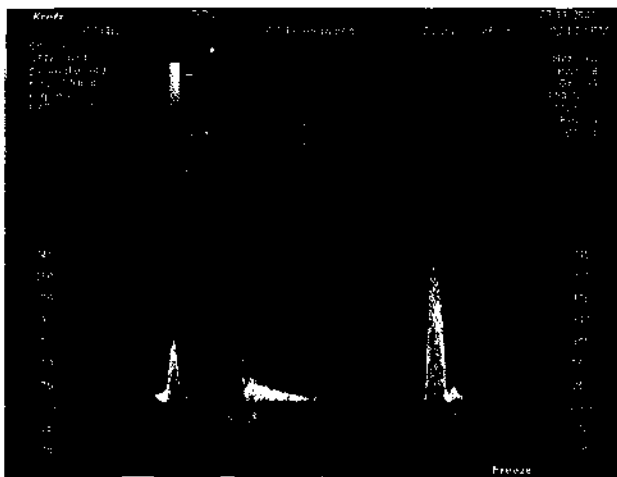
Celiac axis stenosis. Celiac axis stenosis in isolation is rarely symptomatic because of the generous anastomoses in the gut's blood supply, but, because it usually occurs in arteriopathies, two or more of the arteries are often affected. The acceleration of the blood crossing the narrowing produces fast flow on the Doppler study (here rising to more than 4 m/second, shown in the lower panel) together with flow disturbance in the form of eddies that give slower flow signals as well as the very high-velocity signals. These result in a tracing in which all velocities are more or less equally represented, so that it appears as solid white from baseline to maximum velocity.
